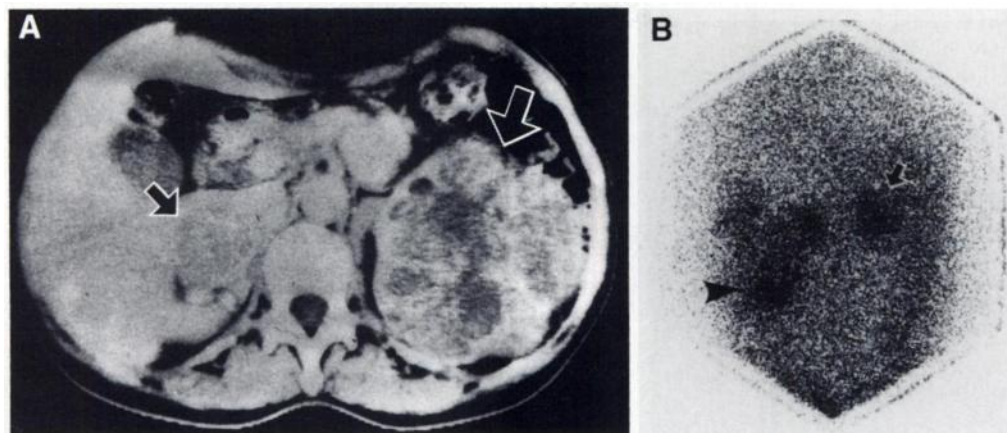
CT scan (A) demonstrates a left renal tumor (large arrow) and a right adrenal tumor (small arrow). A posterior image 8 days after injection of NP59 (B) shows increased uptake in the right adrenal gland (arrow) and diffuse distribution of radioactivity (arrowhead) under the left adrenal gland.
